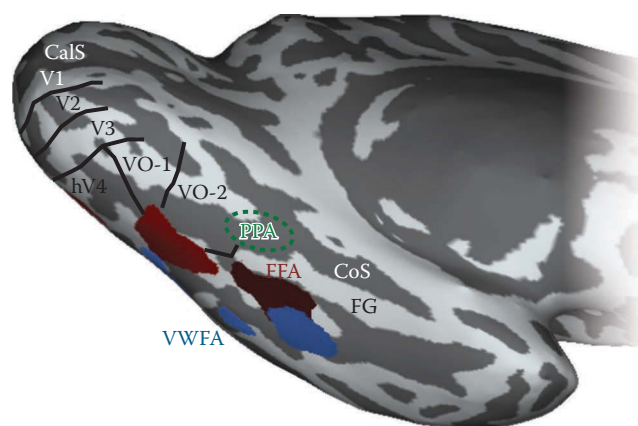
Stimulus-specific visual areas on the ventral surface of temporal cortex. A smoothed rendering of a left hemisphere, seen from below and medially, shows the locations of visual areas in ventral temporal cortex that are highly responsive to specific types of visual images. The visual word form area (“VWFA,” blue) and fusiform face area (“FFA,” red) were identified by functional MRI localizer experiments in which the subject viewed a variety of different stimuli; the blue and red regions were most strongly activated by images containing words or faces, respectively. Both the face- and word-selective responses comprise multiple patches (more posterior regions are filled with lighter shades), consistent with recent observations about category selective regions in ventral visual cortex (Grill-Spector and Weiner 2014, Weiner and Grill-Spector 2012). The approximate location of the parahippocampal place area (“PPA,” green) is identified by comparison to previous papers. Several visual maps are shown in black outline. The PPA overlaps known visual field maps. (Adapted from a figure provided by Kendrick N. Kay, personal communication.)
